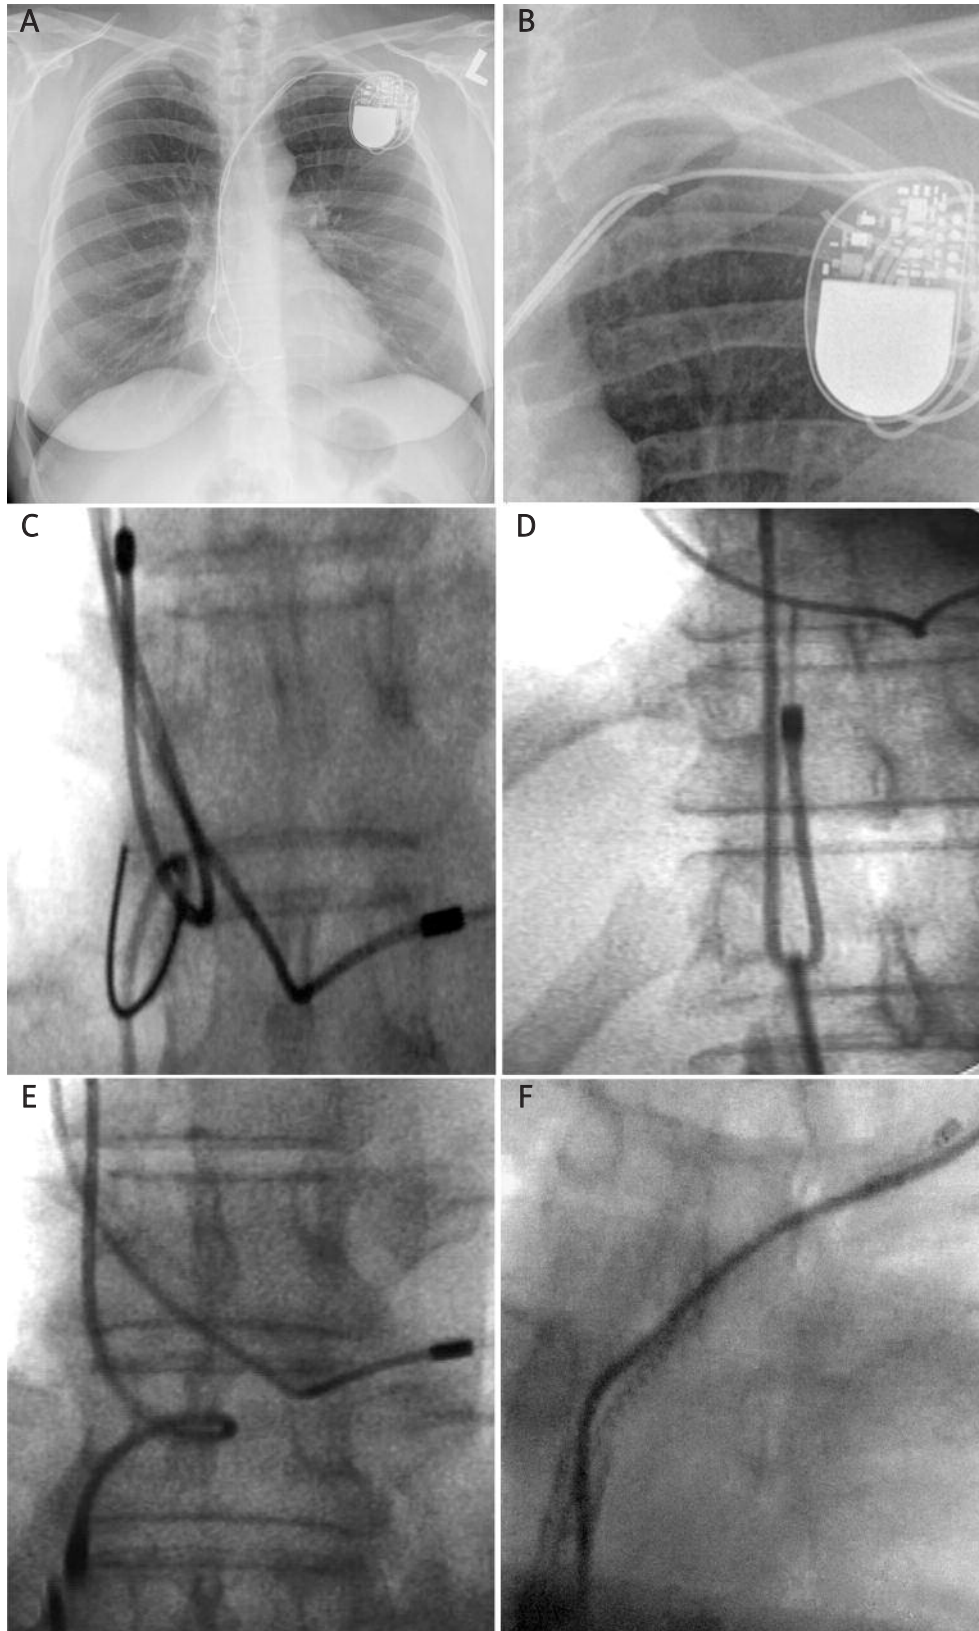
Anteroposterior (A, B) chest radiographs showing the fractured atrial lead with its proximal end anchored in the left subclavian vein, the intact ventricular lead and the DDD pacemaker. Removal of the atrial lead dislodged into the subclavian vein using the femoral approach. C – A pigtail loop was formed to free the head or the proximal end of the adhered atrial lead. D – The atrial lead was pulled into the femoral vein using the pigtail loop with the Dotter basket. E – The freed head was grasped with the Dotter basket. F – The angiographic Teflon sheath was advanced over the elongated atrial coil and counter-traction was applied to free the adhered proximal end
